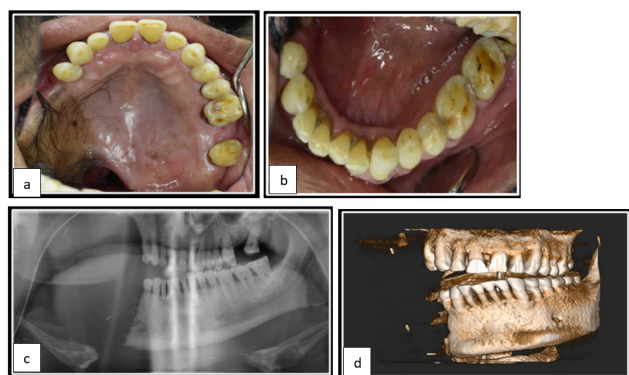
Pre-op intraoral features a): Maxilla, b): Mandible, c): Orthopantomograph d): CBCT
